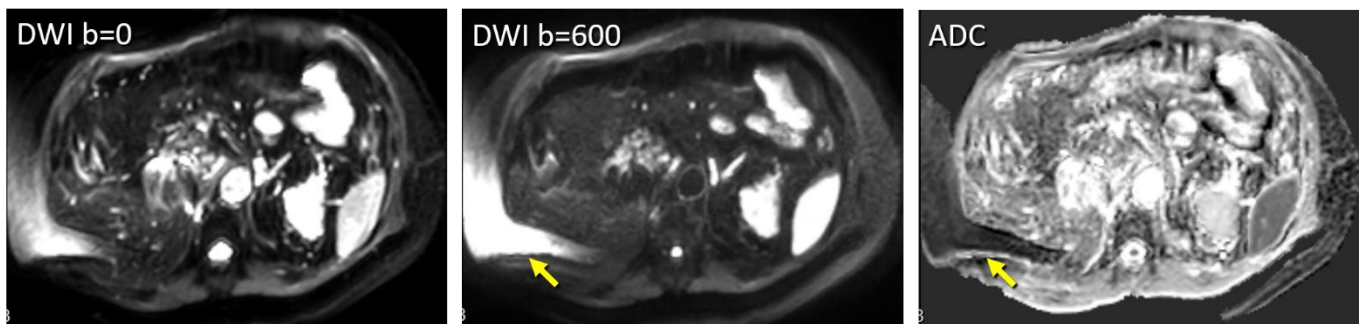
Unsuppressed fat signal spatially shifted on SS-EPI DWI (shifts several cm along phase-encode direction) can obscure the tissue of interest (arrow). Exceptionally low ADC of fat renders ADC meaningless in tissue superimposed by a residual fat signal.
